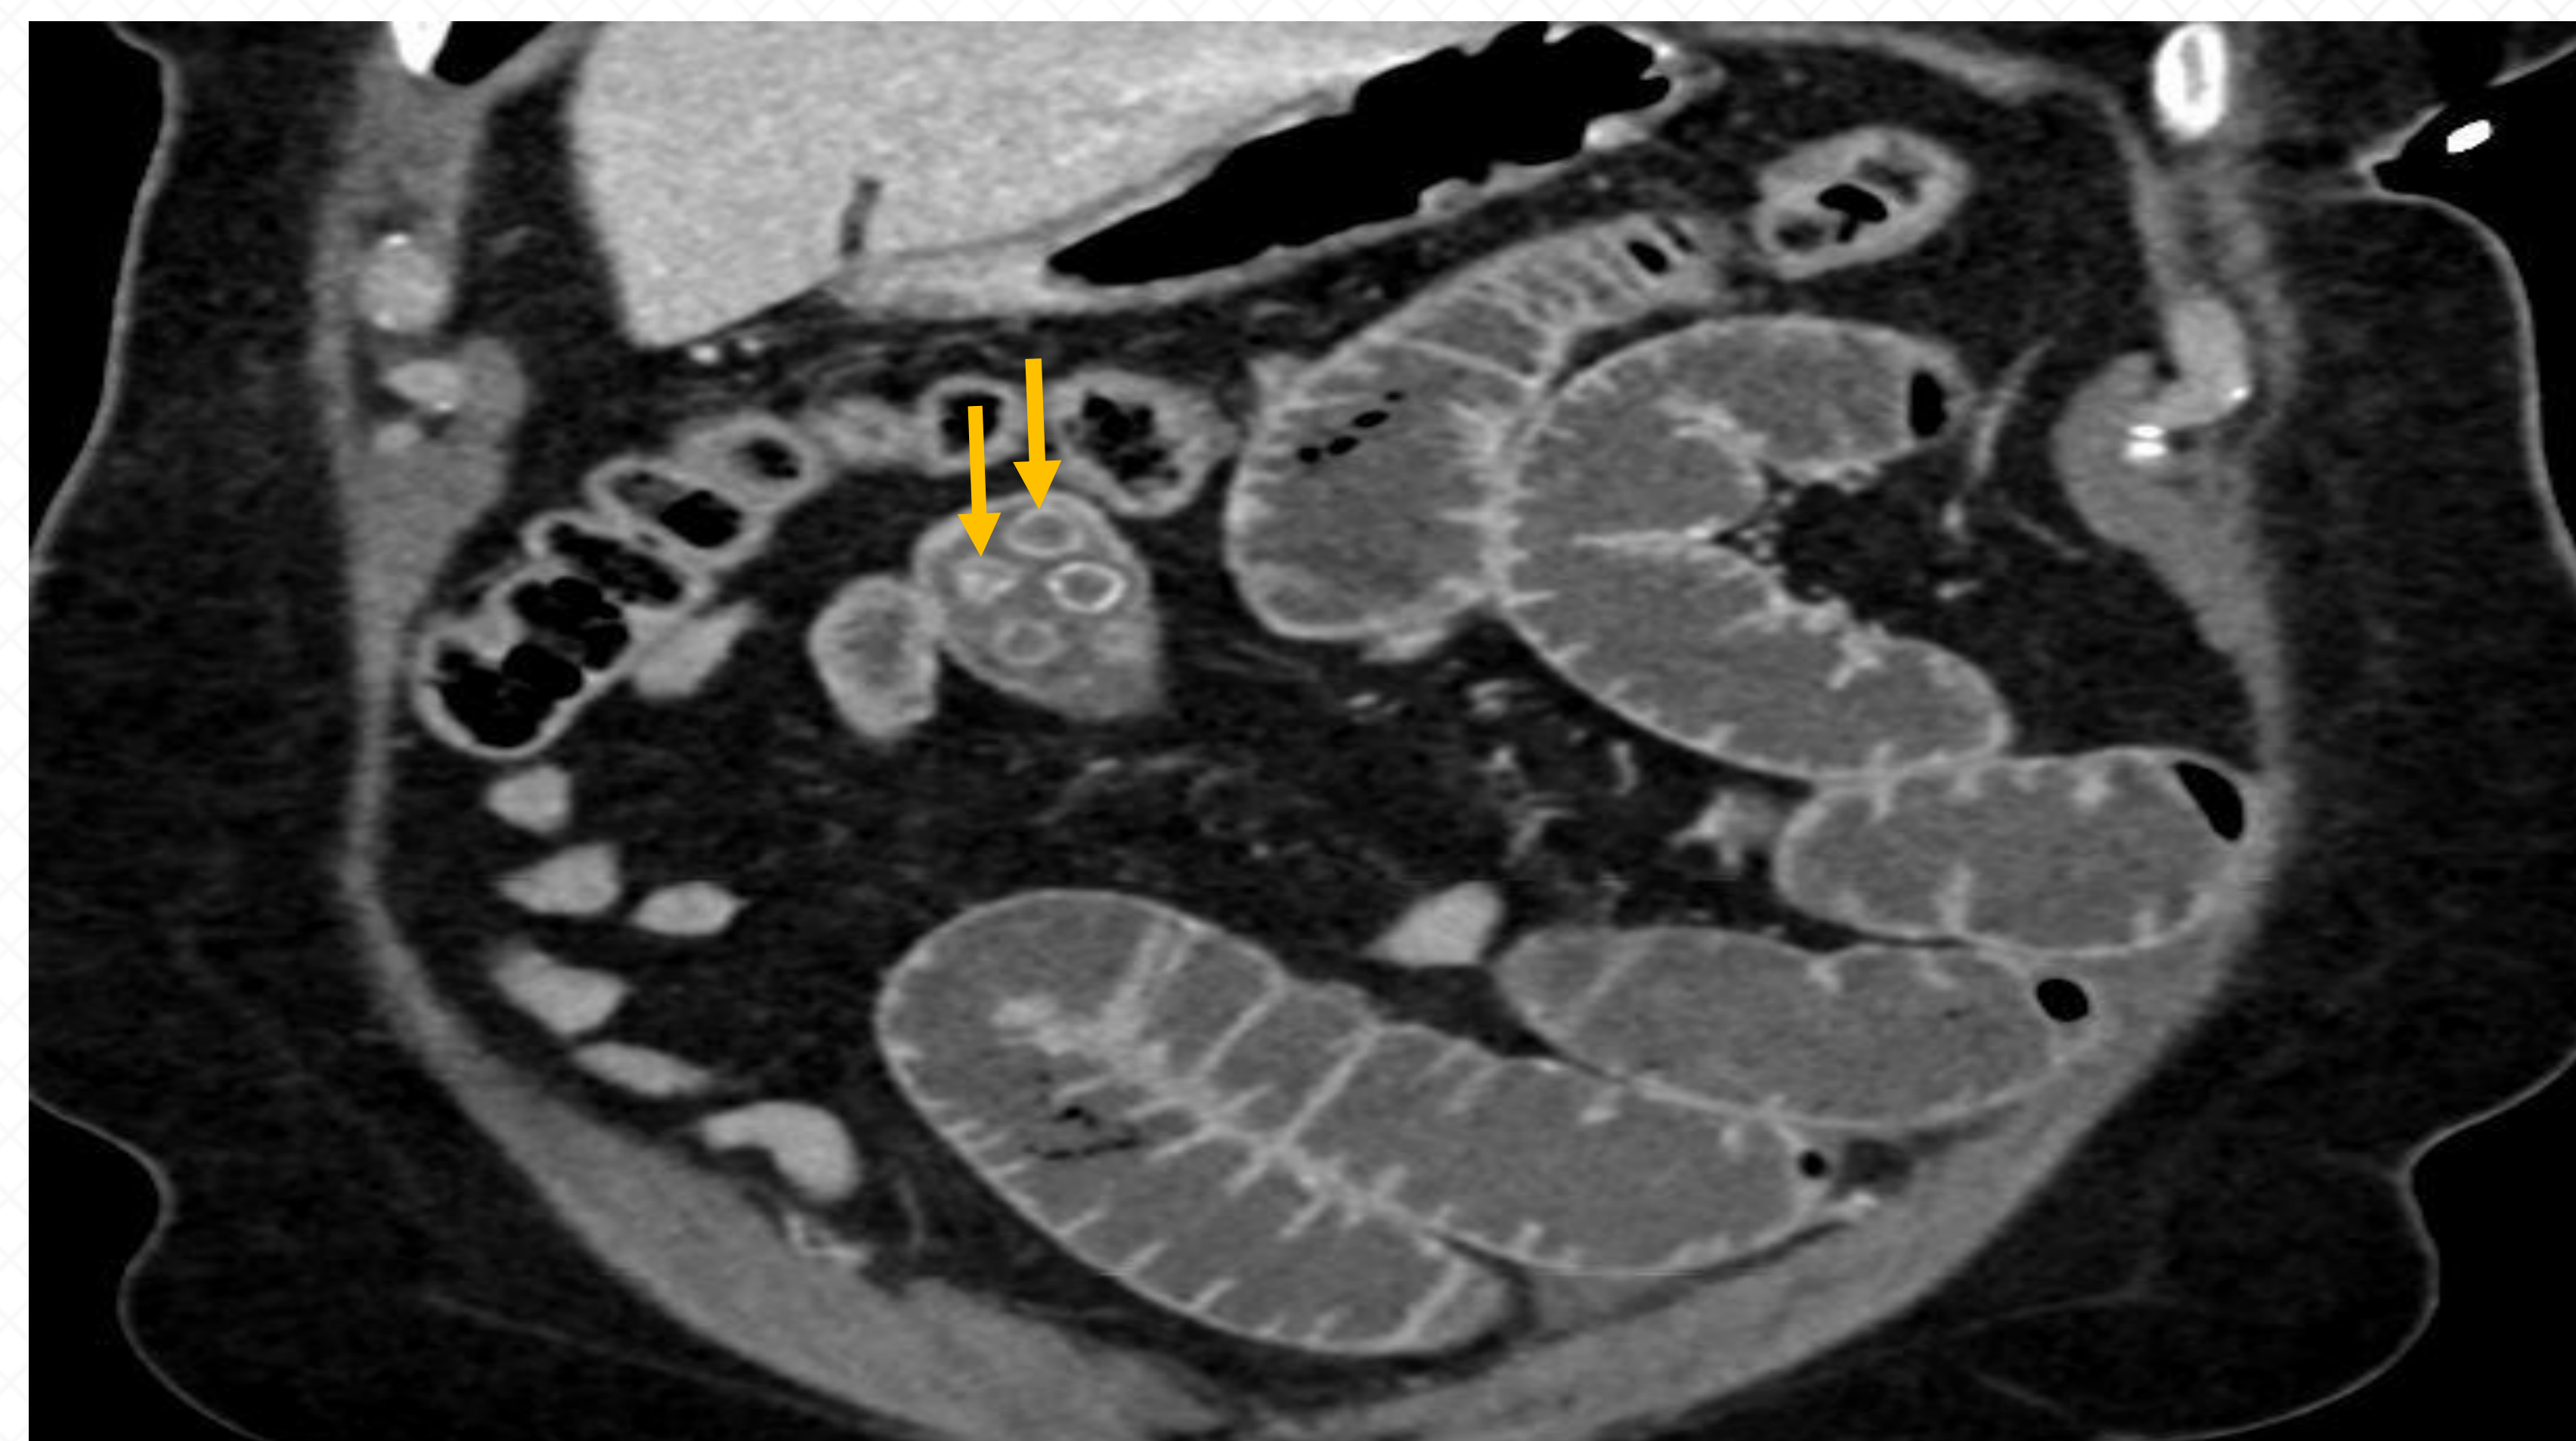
CT scan image of dilated small bowel with intraluminal gallstones seen (arrows)
